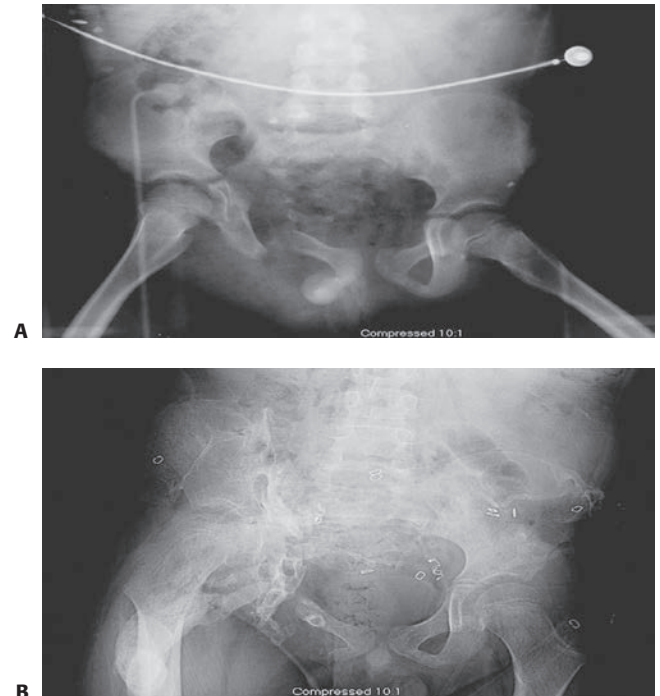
A: Open pelvic fracture with severe displacement. B: The soft tissue injury precluded pelvic reduction and fixation. This radiograph shows remarkable late deformity.
